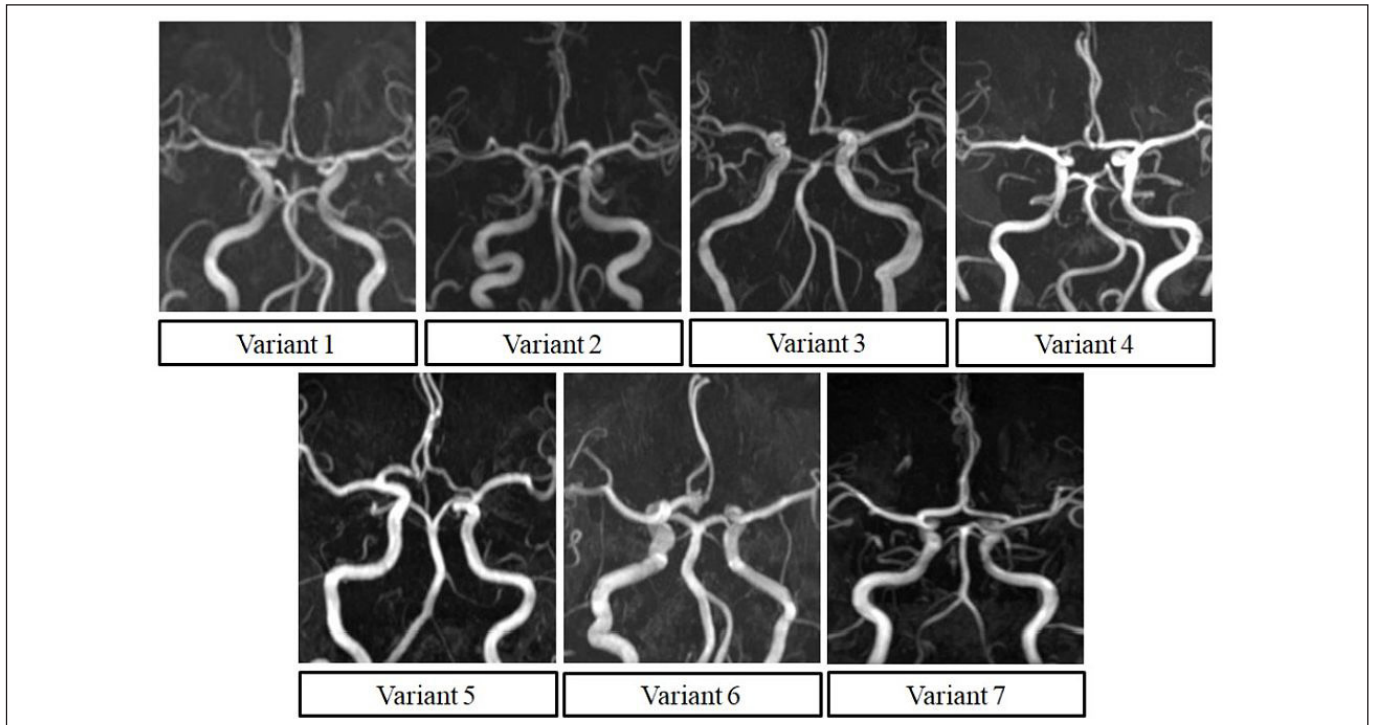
Anatomical variants of ACoAC classified according to types 1-7 on time-of-flight magnetic resonance images.
